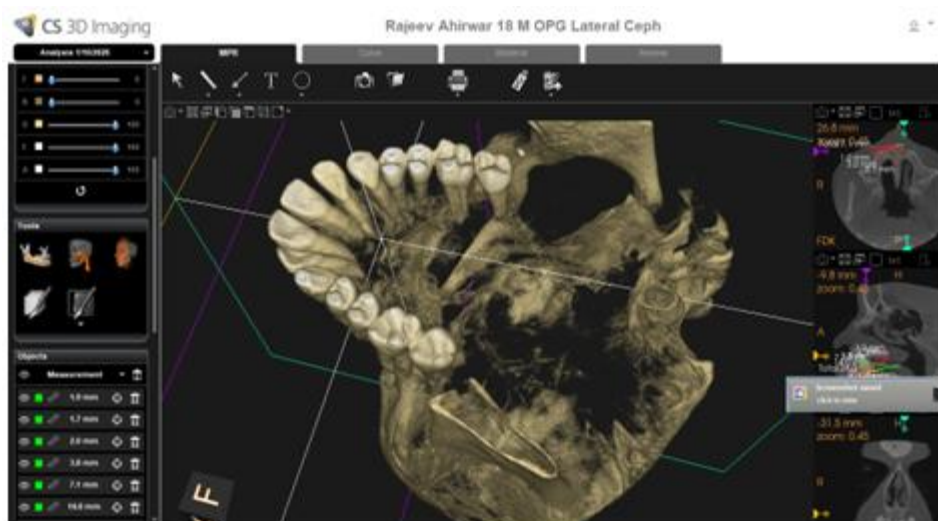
B Carestream 9600 CBCT Software
